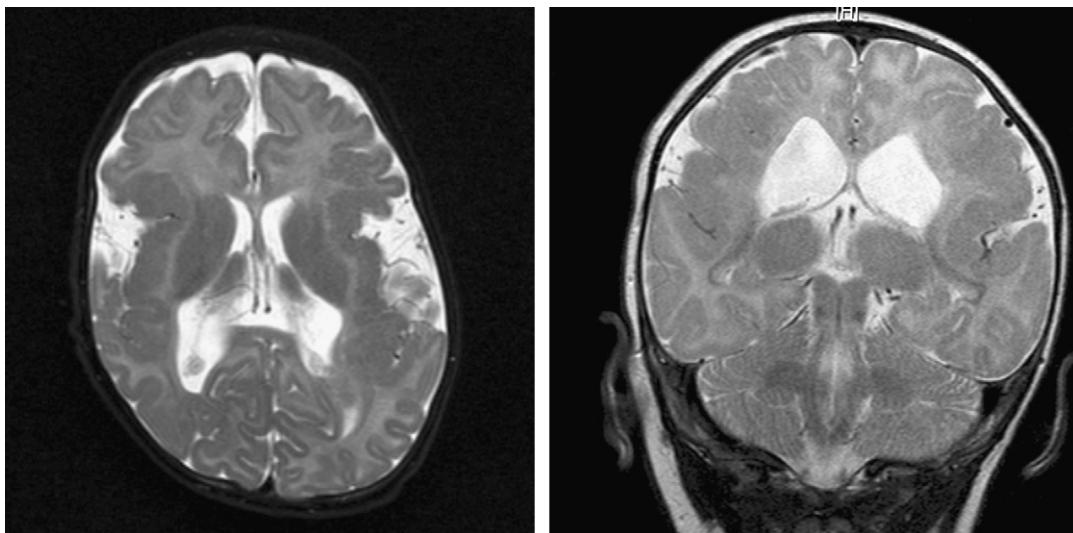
Cerebral MRI at the age of 3 months. Extended symmetric polymicrogyria with irregular thickened and abnormally infolded cortex bilaterally on the borders and in the depth of the broad Sylvian fissures as seen in bilateral perisylvian polymicrogyria.
